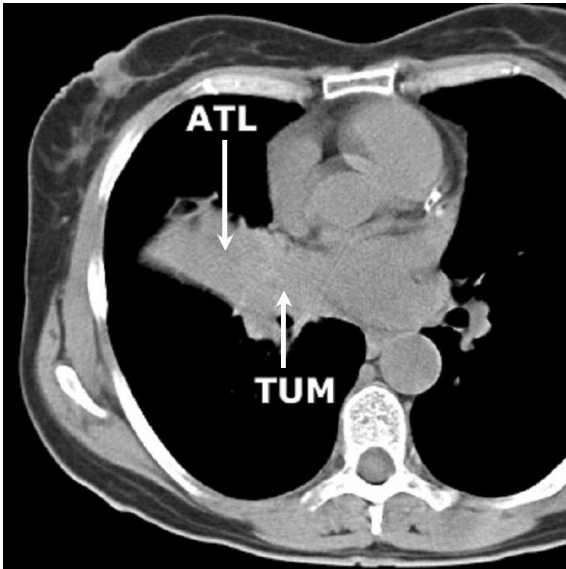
Example slice of typical lung CT image with atelectasis (ATL) and tumour (TUM) regions (left panel) and plots of mean intensity values of the atelectasis and tumour regions for 40 patients (right panel).
